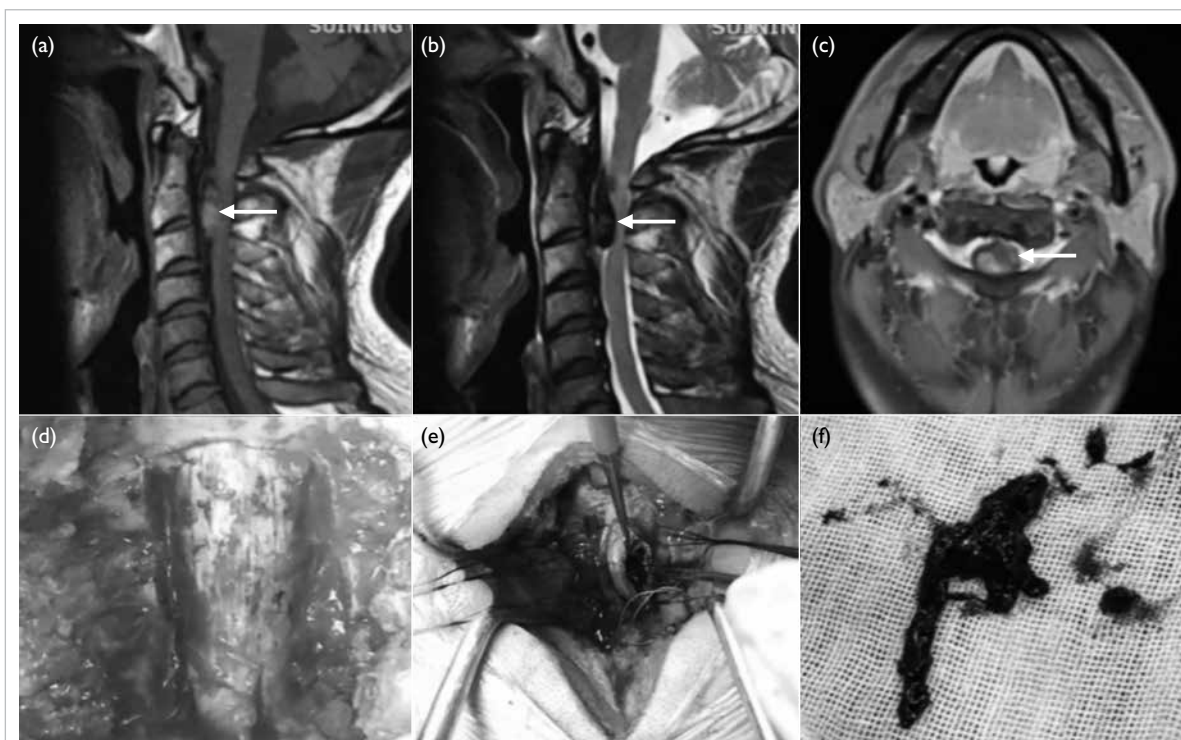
Cervical magnetic resonance imaging showing a tumour at the C2-C3 level (arrows) with a hyperintense signal on T1-weighted imaging (a), and a predominantly hypointense signal on T2-weighted imaging (b: sagittal; c: axial). Intraoperative images showing grey-black dura (d), black tumour exposed after dural incision (e), and tumour post-removal (f)
